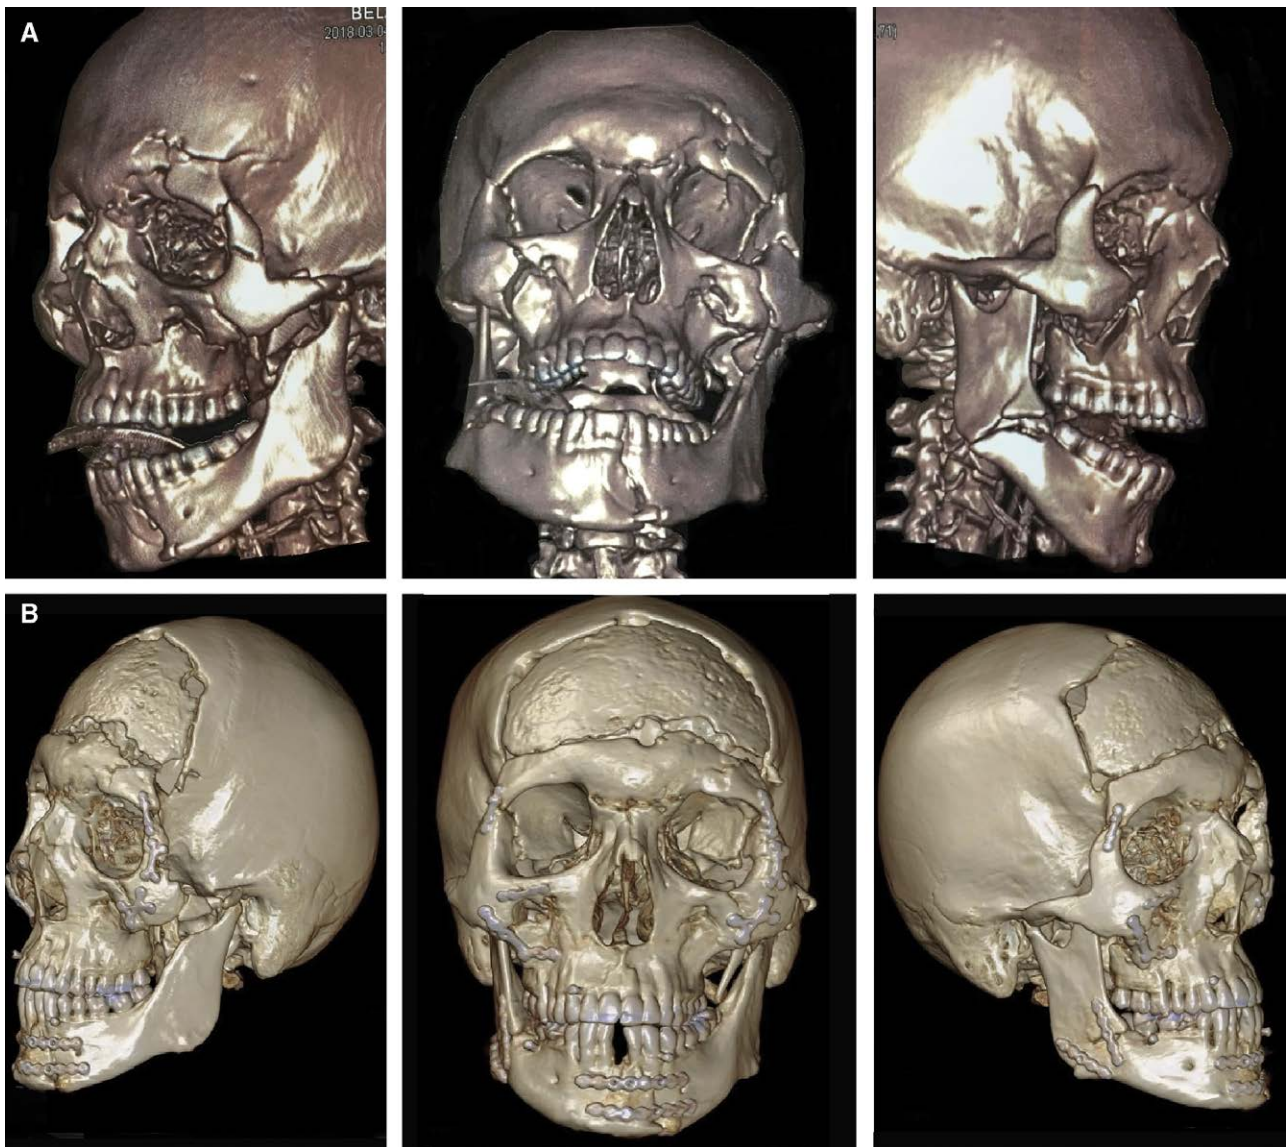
Preoperative 3D-CT scans (A) of a 27-year-old male patient who had presented to our department with malunited facial fracture. (B) Nine weeks after the initial trauma (upper row). 3D-CT scans of the same patient after 6 weeks postoperatively with an optimal occlusion (lower row).
